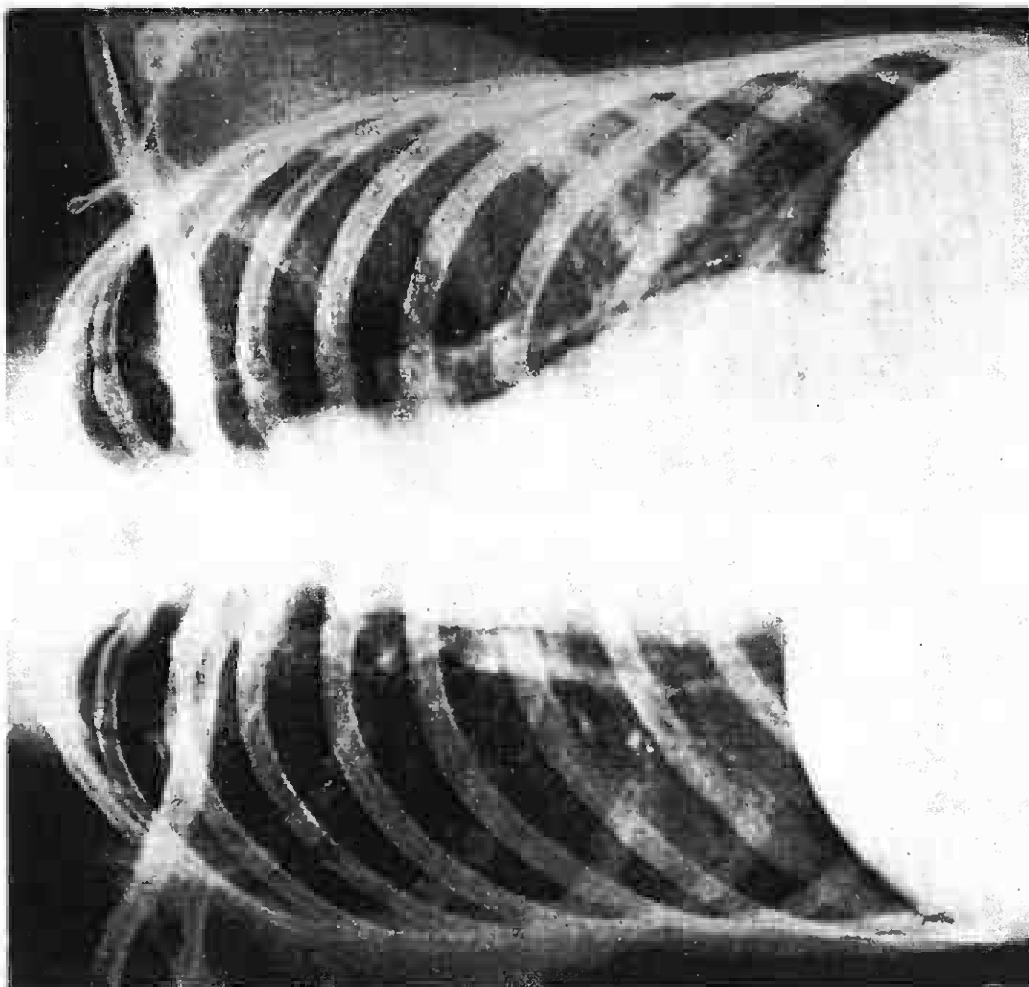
Case 9. Chinese female, aged 52 years. She had worked in the granite quarry for more than 21 years in the last 4 years as crusher-stone trucker. Chest X-ray film taken in 1955 shows discrete opacities extending within the medial 2/3 of the lung field — interpreted as simple pneumoconiosis. Category 1/.
